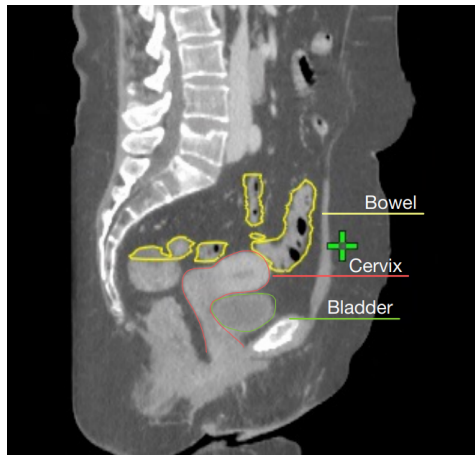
CT scan of a female patient
